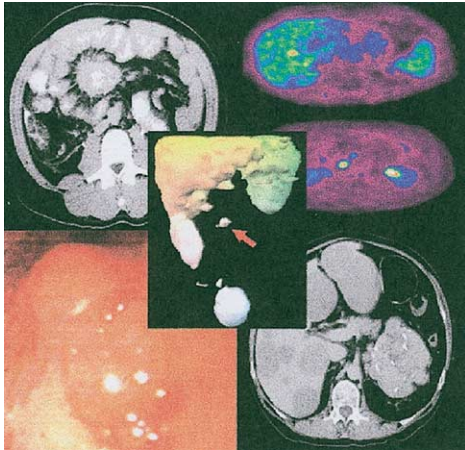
Diagnostic modalities. CT of a carcinoid tumor with central calcification and the characteristic desmoplastic response with spiculation of the adjacent mesentery (*top left*). ^{11}C -5-HTP positron emission tomography (*top right*). *Top image* is a hepatic metastasis, and *bottom image* an axial projection of mesenteric lymph nodes in a midgut carcinoid (*below*). CT of carcinoid hepatic metastases (*bottom right*), and a gastroscopic view of 2 carcinoid polyps in a pernicious anemia patient (*bottom left*). In the *center*, an Octreoscan demonstrating a peritoneal metastasis (*red arrow*) in a patient with fibrotic, disseminated small intestinal carcinoid disease.
